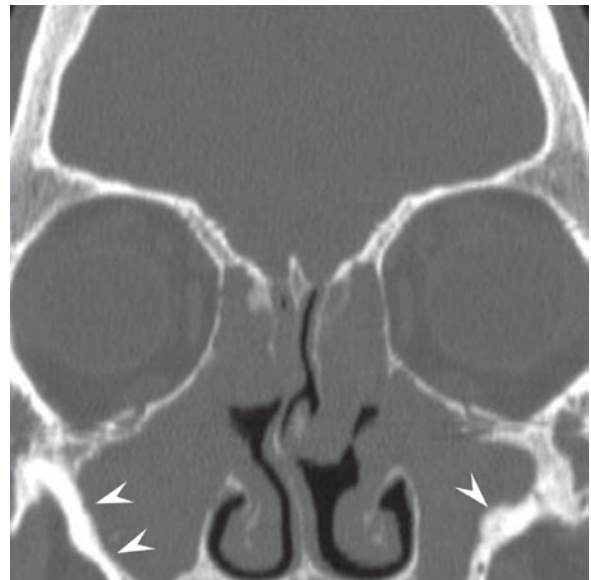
Cystic fibrosis. Coronal CT in a patient with cystic fibrosis shows fewer convex surfaces than in patients with NP, relative sparing of the nasal cavity, and extensive osteoneogenesis (*arrowheads*). Compare with Fig. 6.9
